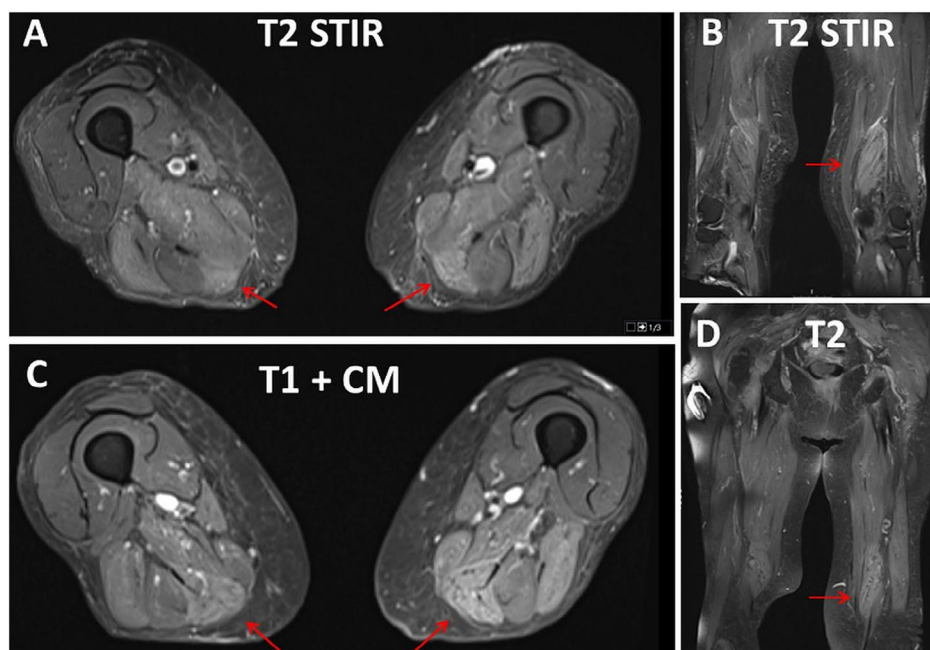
Magnetic resonance imaging of thighs bilaterally showing high short tau inversion recovery (STIR) signals in the anterior, medial, and posterior thigh musculature with surrounding edema compatible with myositis. Axial STIR images (panel A), coronal STIR images (panel B). On T1 with contrast, the muscles were enhanced (panel C). On coronal T1 images without contrast, the muscles appear isointense (panel D).
